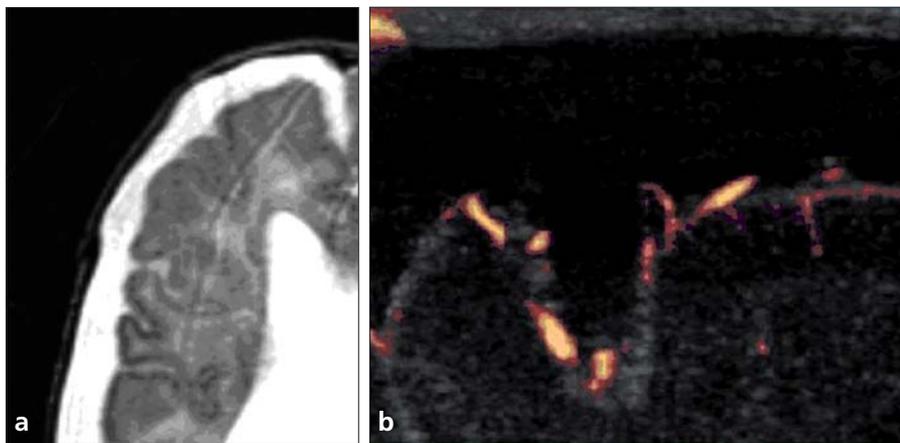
a, b. A case of subdural hematoma in which cortical veins were not visualized on axial T2-weighted MR image (a). Cortical veins are visualized as displaced toward the parenchyma on power Doppler US examination of the same case (b).
